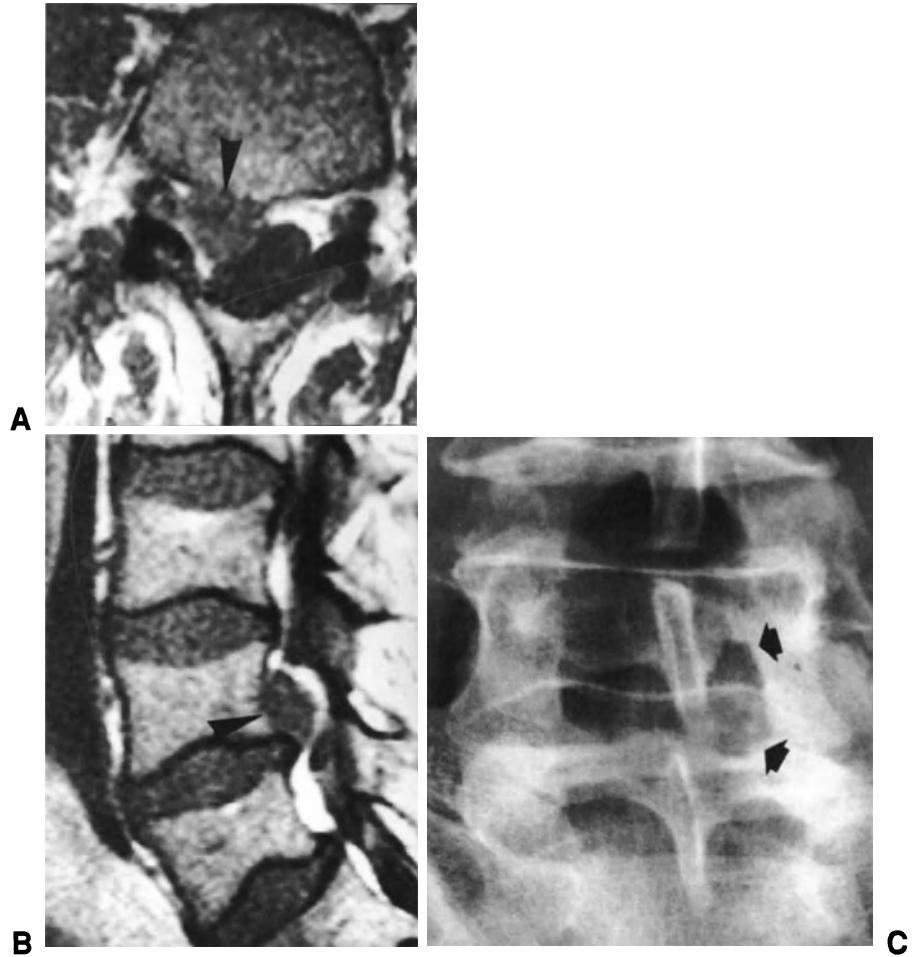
(A) and (B) Spin-echo T1-weighted axial and sagittal MR images showing a large disc fragment migrated proximally to the L4-L5 disc (arrowheads). (C) Postoperative radiograph showing the proximal enlargement of laminotomy (arrows), which was necessary to remove the large migrated fragment.
